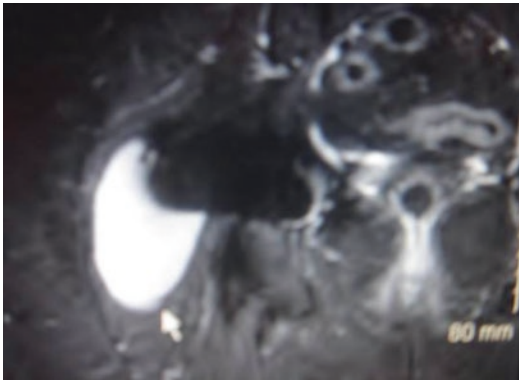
Cross-sectional MRI of a cystic ALTR lesion in a MoM THA
